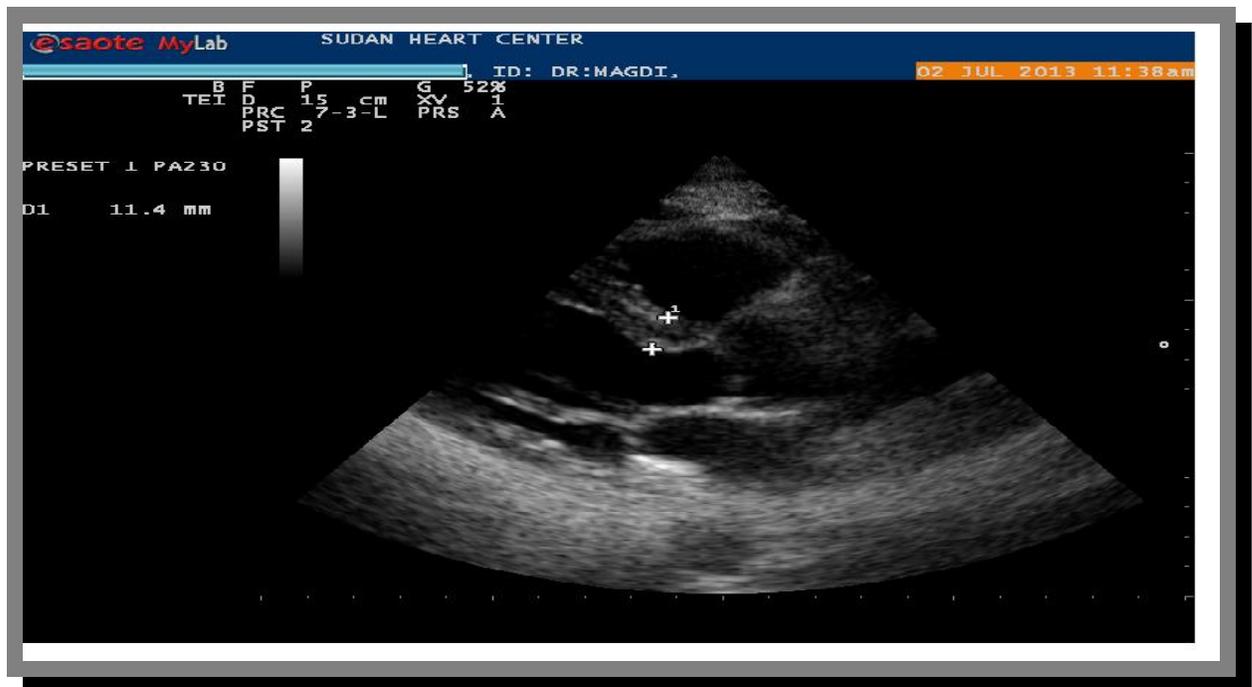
Parasternal long axis shows IVS in mildly abnormal(11.4mm).
